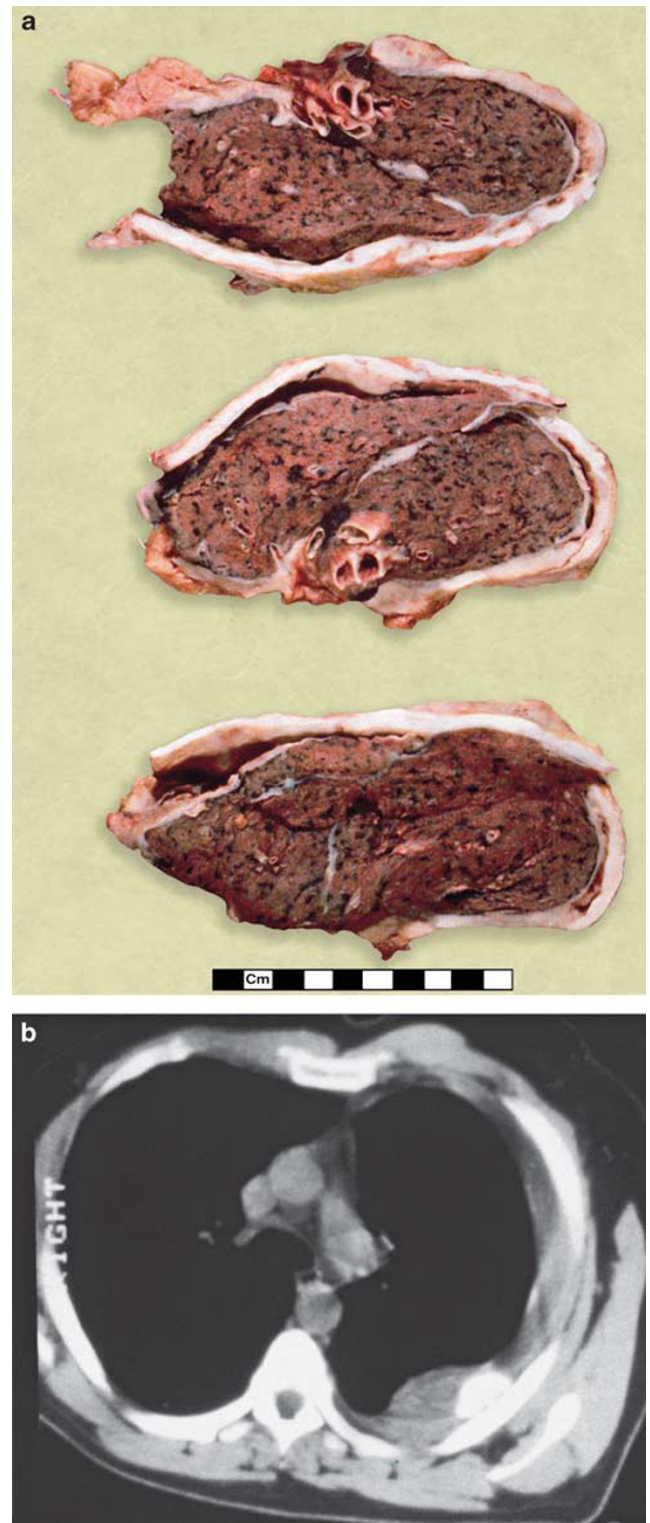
Gross distribution of disease. (a) Horizontal sections of the post-mortem lung showing encasement by pleural sarcomatoid mesothelioma. (b) Computed tomography of chest showing tumor as an area of pleural thickening with focal bone formation. Figure 1b reprinted with permission from Sporn and Roggli (2004).¹⁵
